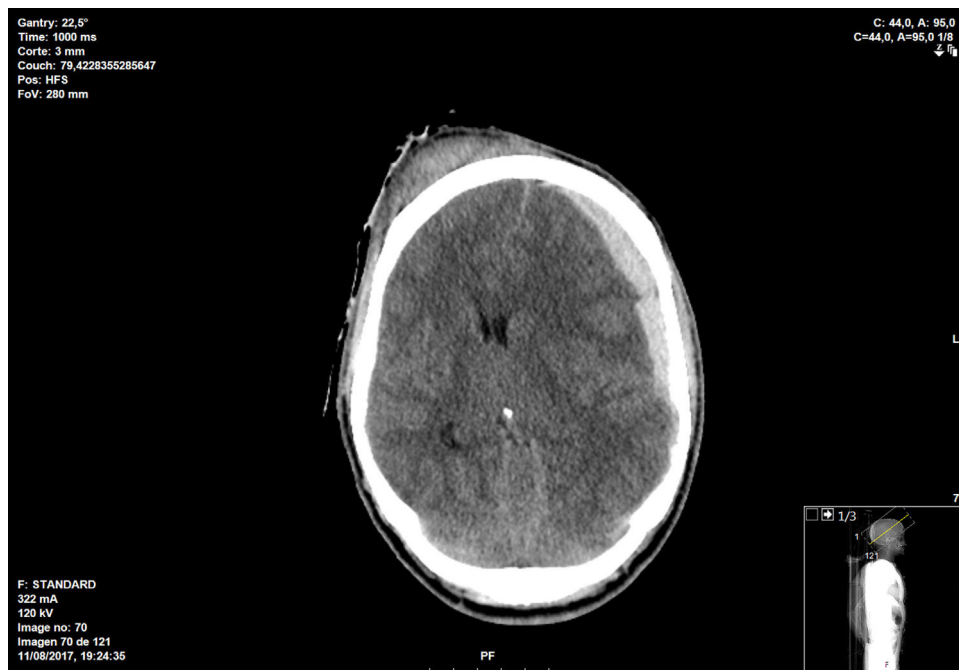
CT scan showing hemispheric subdural hematoma with middle line shift.
